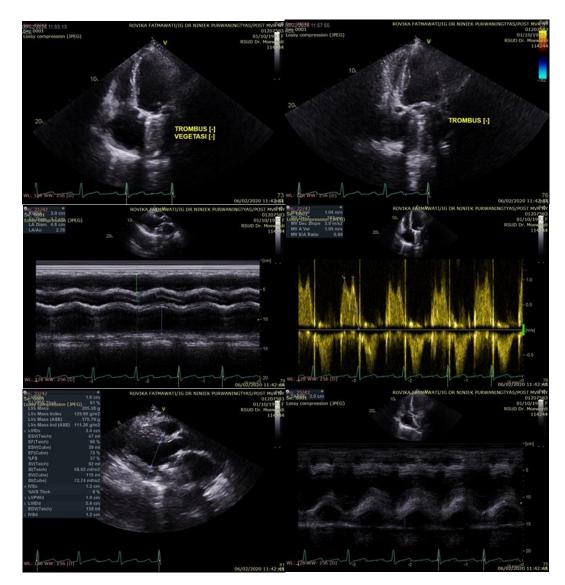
Patient echocardiography's
